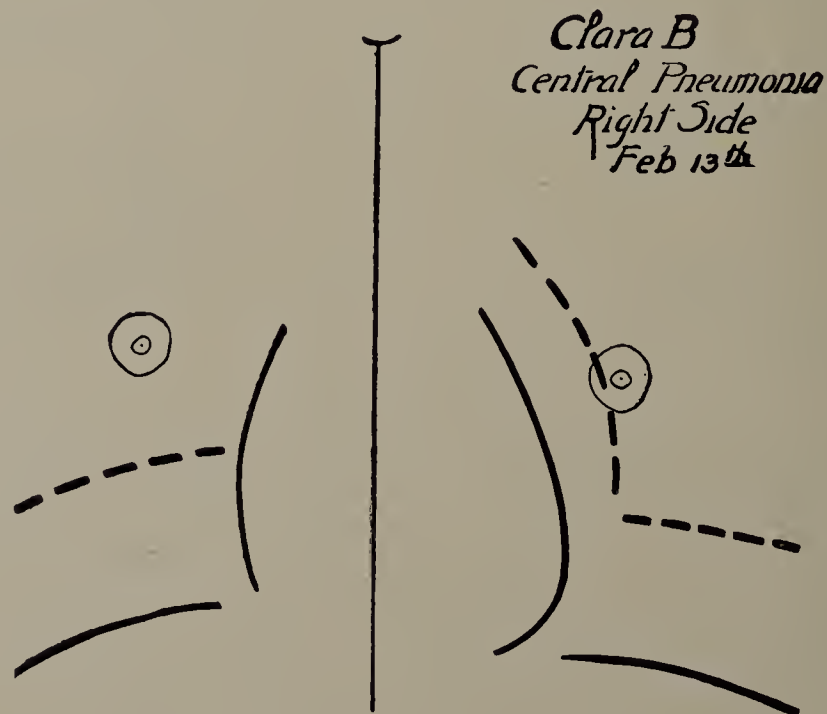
Clara B. February 13. Second X-ray tracing with screen. Lung clear ; good excursion of diaphragm. (One-third life size.)
